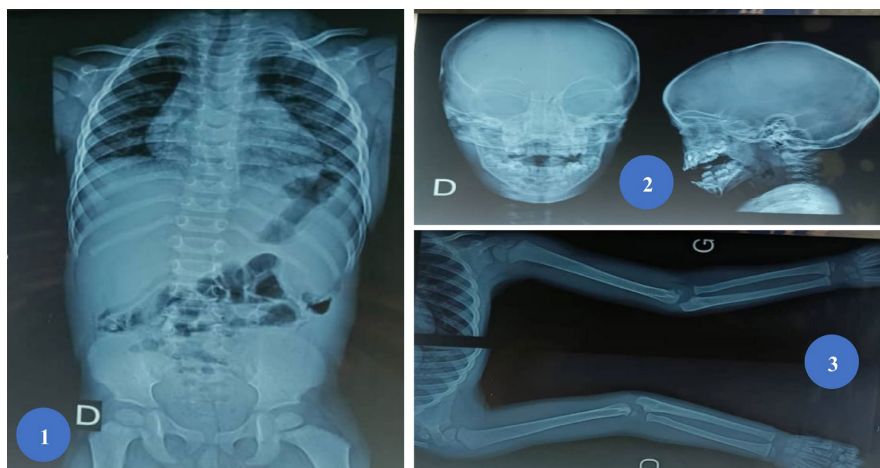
X-ray of the rest of the body (1) front thoraco-abdominal, spine and pelvis X-rays; (2) front and side skull X-rays; (3) front upper limb X-rays.
